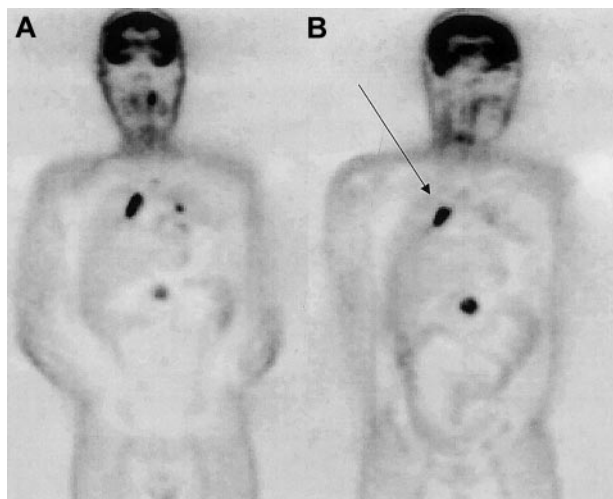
Example of a positive study. Pretransplantation [^{18}F]FDG-PET scan in a patient with diffuse large B-cell lymphoma showed intense residual [^{18}F]FDG uptake (arrow). After HDT/SCT, the patient had a relapse and died of progressive lymphoma (PFS, 104 days; OS, 314 days). (A) Scan before the start of treatment; (B) Scan before transplantation.
